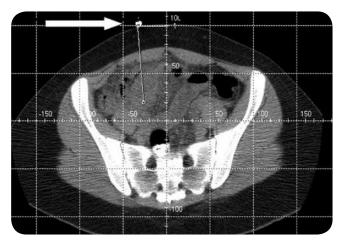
An axial CT image through the abdomen showing measurements taken before catheter placement.
